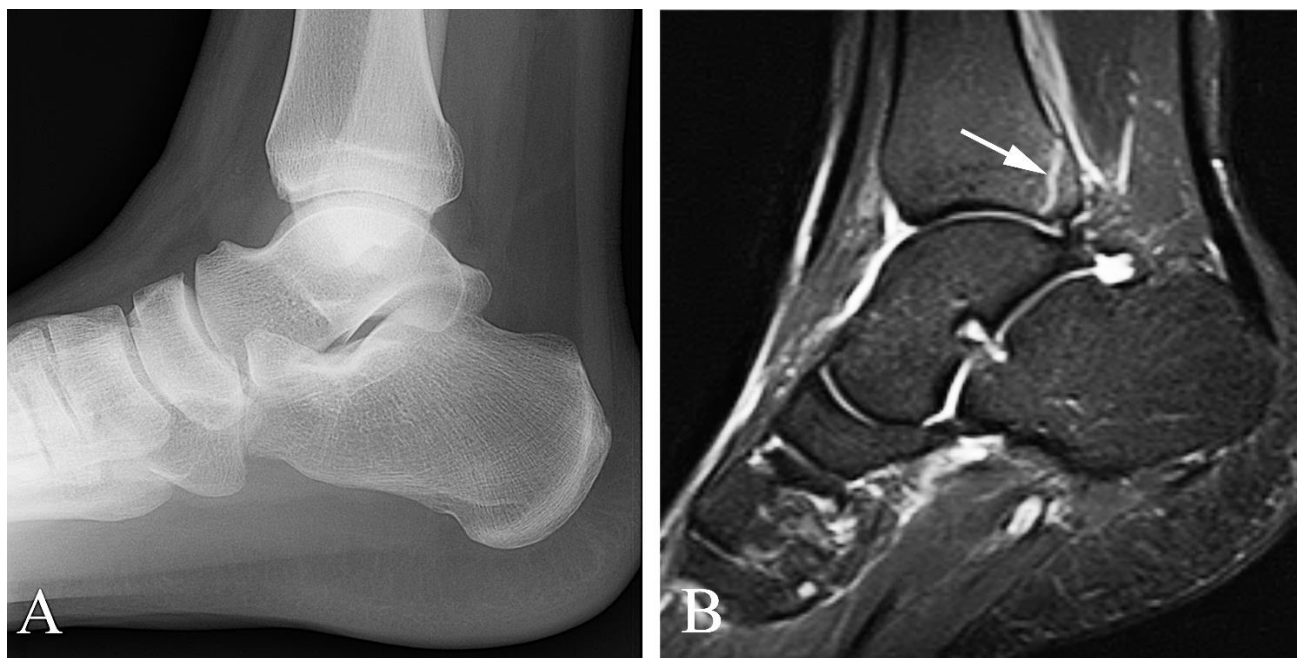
Radiographically occult fracture in a 28 year old man with pain following trauma. A. Lateral plain film examination of the ankle is normal. B. Sagittal MR fat-suppressed T2 weighted image demonstrates a fracture line (arrow) through the posterior, distal tibia (the so-called “posterior malleolus”).
